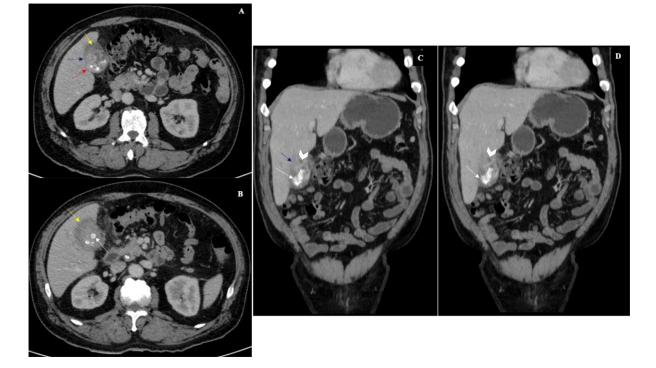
Contrast enhanced Computerized tomography (CT) scans of the abdomen in axial and coronal views from (A–D) demonstrate irregular diffuse mural wall thickening of the gallbladder (red arrows) along with few hypoattenuating mural nodules (white head arrows). Multiple hyperdense calculi (white arrows) and pericholecystic fluid collection(yellow arrows). Poor fat planes to the adjacent liver parenchyma are noted (blue arrows).
